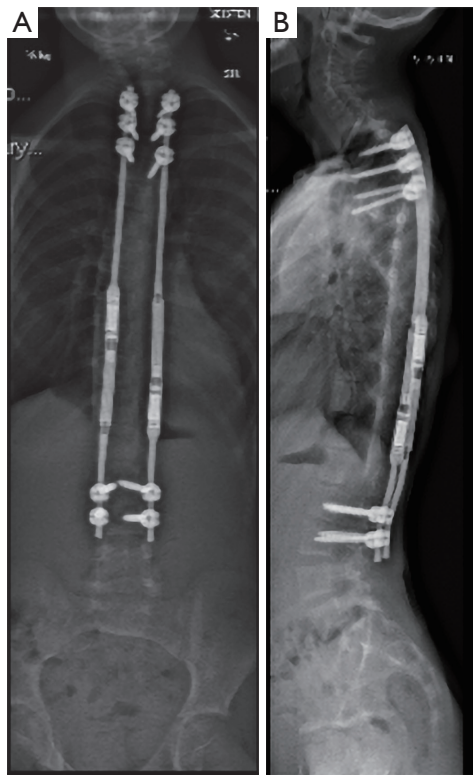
Standing posteroanterior (A) and lateral (B) spinal radiograph 3 years after index surgery at the age of 8 years. Radiographs demonstrates well-aligned and corrected spinal deformity, but the proximal thoracic pedicle screws seem to be pulling out.
